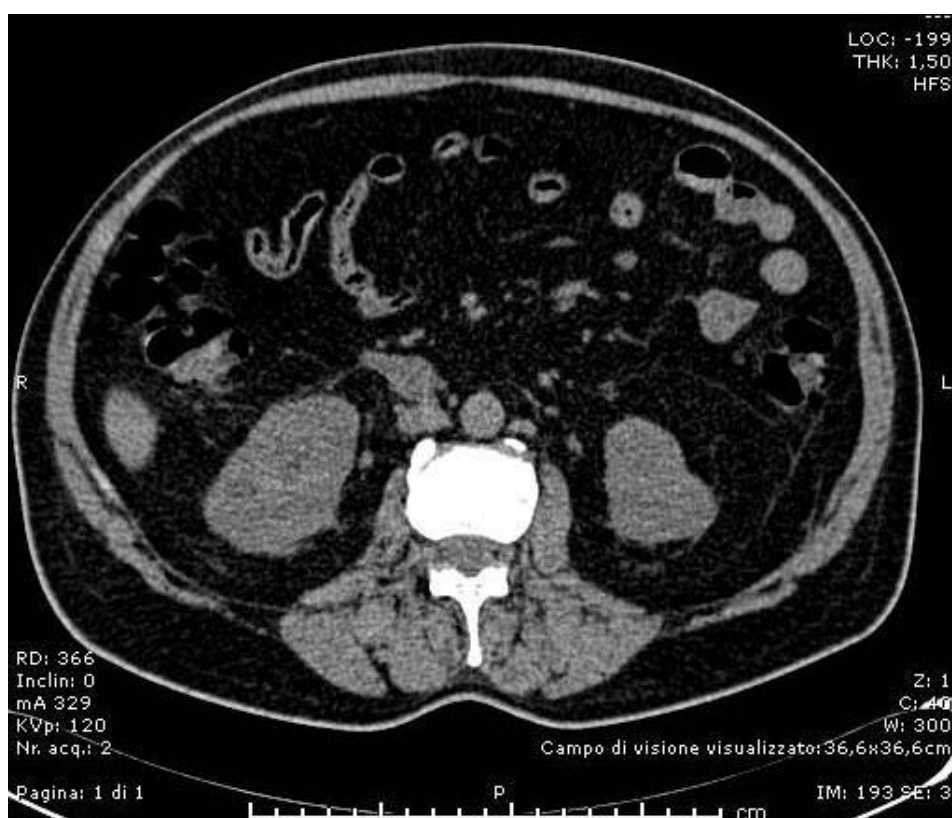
Abdomen CT scan with a linear foreign body between the duodenum and the IVC
